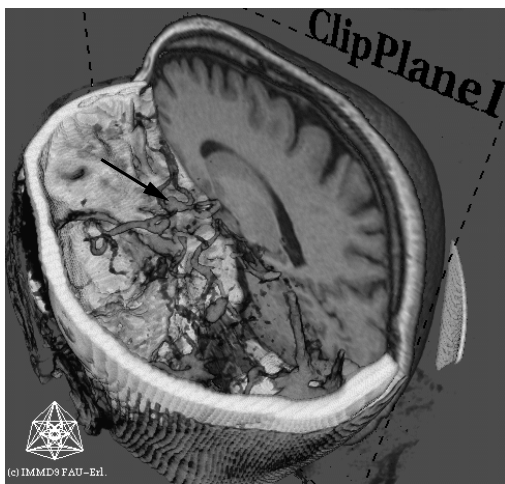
Fusion MR(T1) and CTA showing aneurysm.
